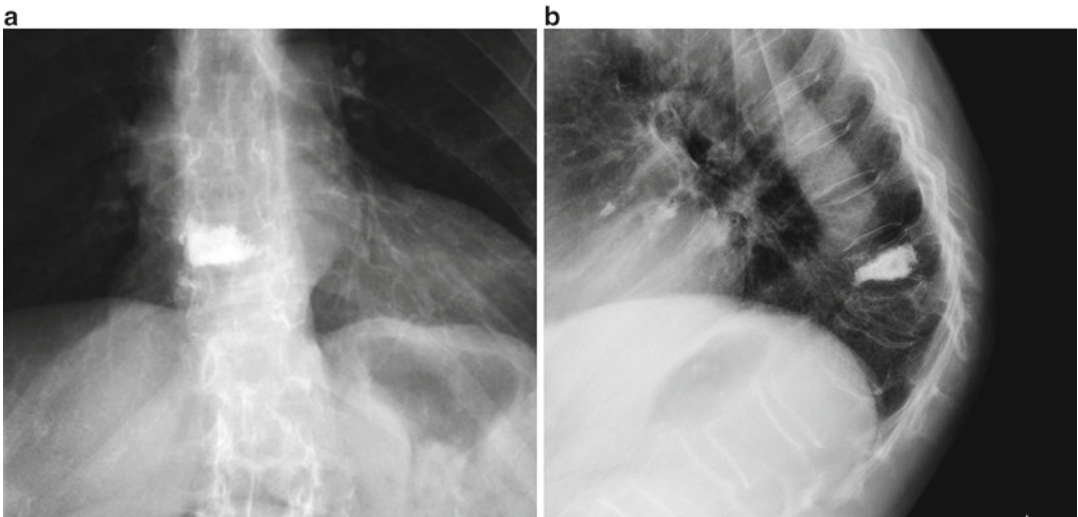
(a) AP preoperative radiographs demonstrating compression fractures at T11 and T12. (b) Sagittal radiographs demonstrating the same pathology
